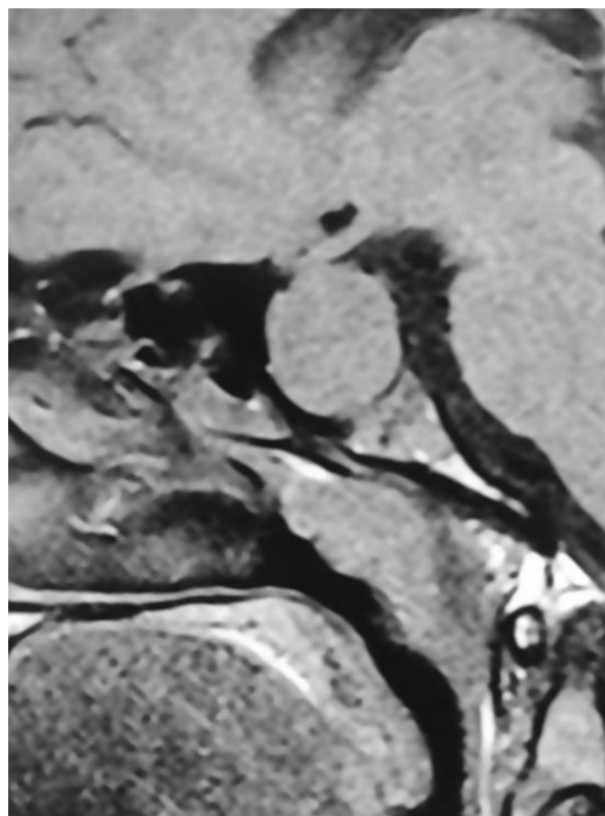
MRI of the brain shows 3.2 × 3.0 × 3.2 cm sellar mass (pituitary macroadenoma) with suprasellar extension, compression of the bilateral optic nerve and optic chiasma.
